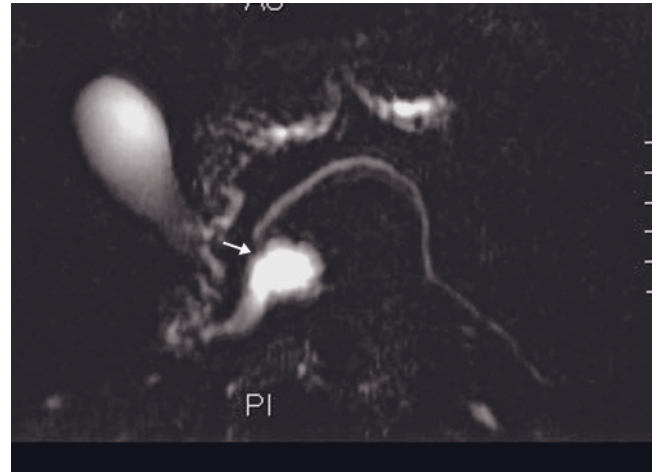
Side-branch IPMN. Coronal (a) and axial (b) T2-weighted SS-ETSE, fat-suppressed T1-weighted gradient-echo (c) and immediate postgadolinium T1-weighted gradient-echo (d) images in a patient with side-branch IPMT demonstrate a 3-cm multilocular cystic mass in the pancreatic head. The lesion does not enhance after gadolinium administration (d).
